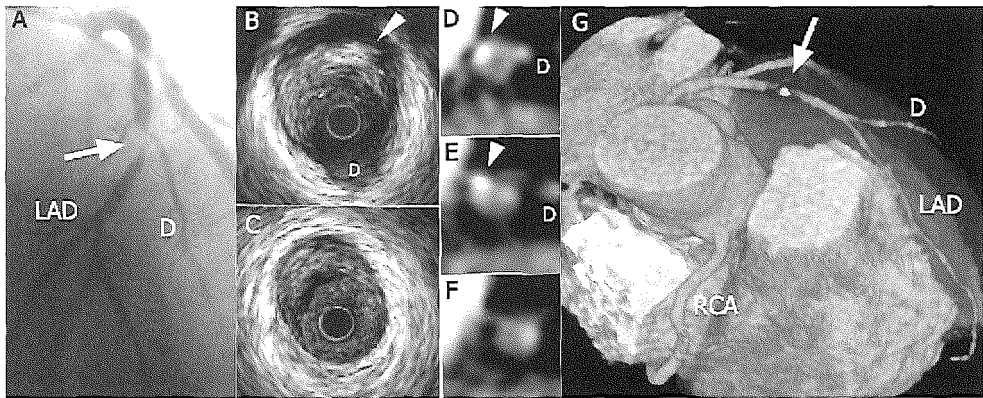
Comparable plaque features with intracoronary ultrasound and multislice spiral CT. Conventional selective coronary angiogram (Fig. A) of the left coronary artery showing a significant lesion (arrow) at the level of the bifurcation of the left anterior descending coronary artery (LAD and the first diagonal branch (D)). Intra coronary ultrasound (Figs. B and C) shows a plaque that is partially calcified (arrow head). Multi planar reconstructions (Figs. D, E and F) of the LAD show cross sectional views of the LAD that correspond with the ultrasound findings. A three dimensional reconstruction of the MSCT angiogram (Fig. G) shows the partially calcified stenotic lesion (arrow). Right coronary artery (RCA). The CT data were acquired with a Somatom VolumeZoom (Siemens, Germany), rotation time 500 ms, detector collimation: 4 x 1.0 mm).
